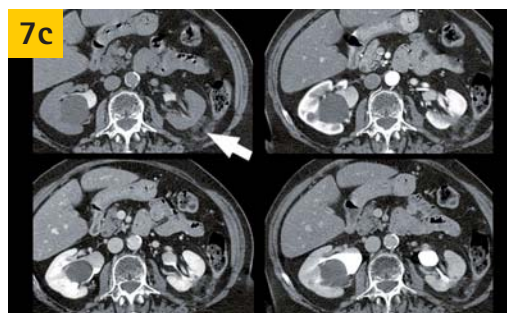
Contrast-enhanced CT at two years confirmed the success of the procedure.
